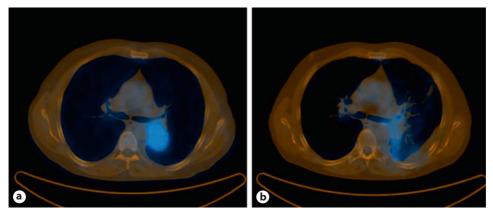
NSCLC of the left lower lobe. T2/N1 tumor. FDG-PET-CT scan. a Before SBRT. b 12 months after SBRT with 5×7.0 Gy (calculated on the 60% isodose). Local lung fibrosis. Complete remission. SUV in PET scan <2. Courtesy of Institute of Nuclear Medicine, MRI, Munich.
